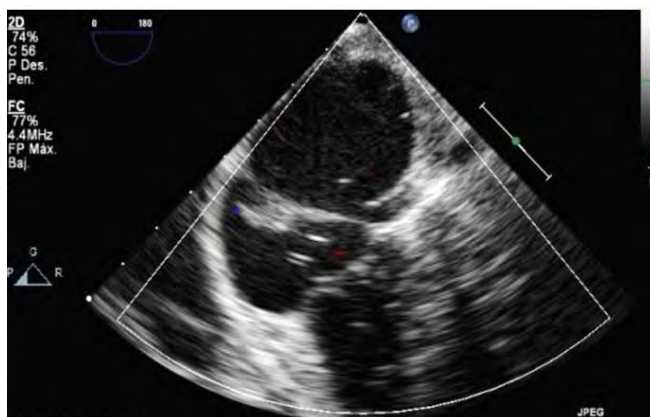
Echocardiogram shows membrane dividing right atrium into two chambers.
